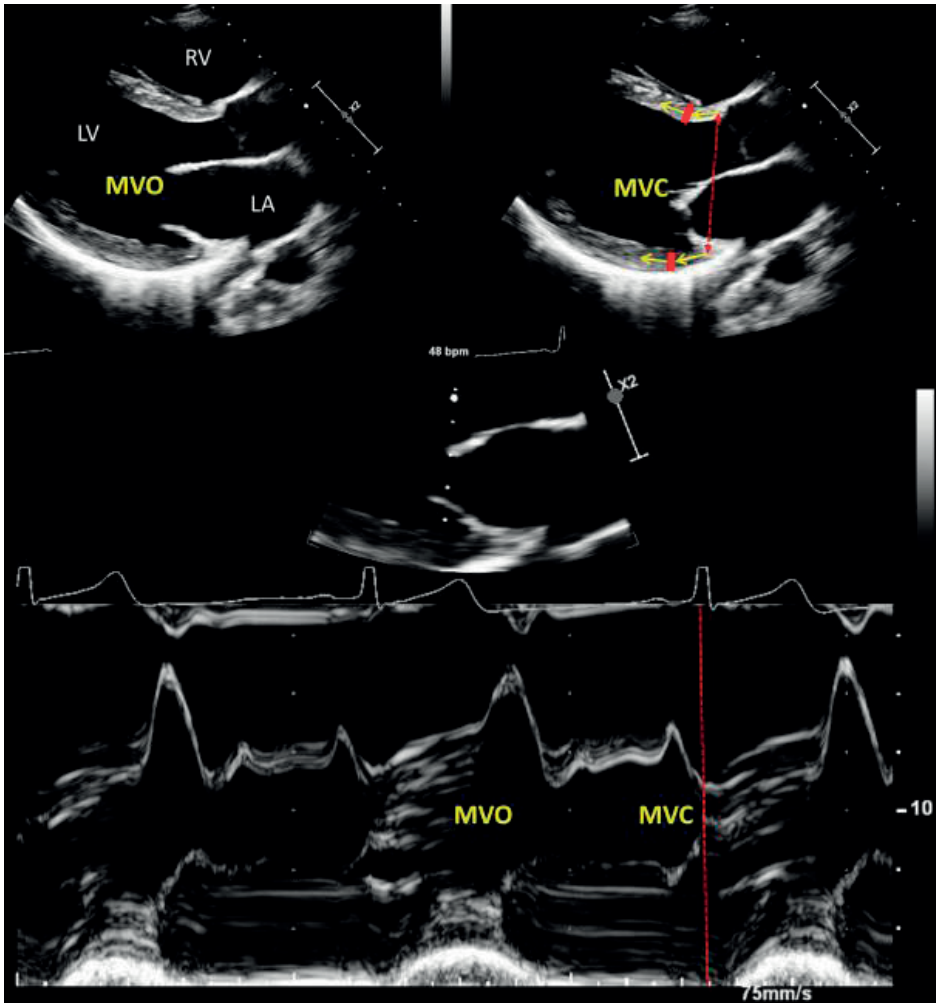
Theoretical model of the shear waves generated by the closure of the valves (source: personal collection). Upper panel: parasternal long axis view, with mitral valve open (MVO, left hand side image) and mitral valve closed (MVC, right hand side image). The closure of the mitral valve (lower panel, M-mode at the tips of the mitral valve as demonstrated in the central zoomed panel) induces a shear wave (red bands) appearing at the valvular annulus and coursing to the apex of the LV (yellow arrows).
